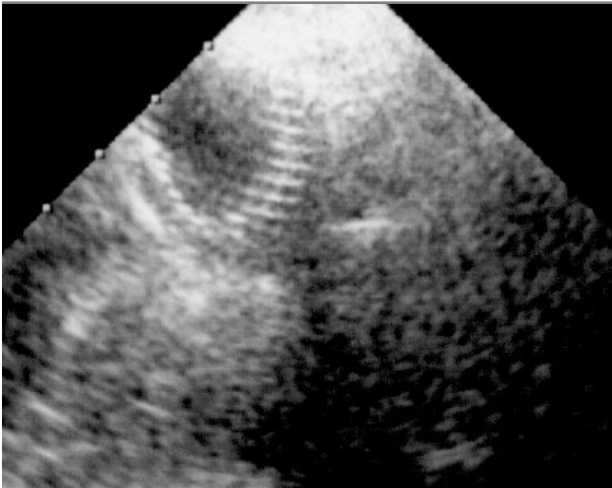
Transesophageal echocardiography showing the expanded smart canula® within the superior vena cava (trans-femoral access) after withdrawal of the guide wire and the mandrel (allows for self-expansion of the cannula)
